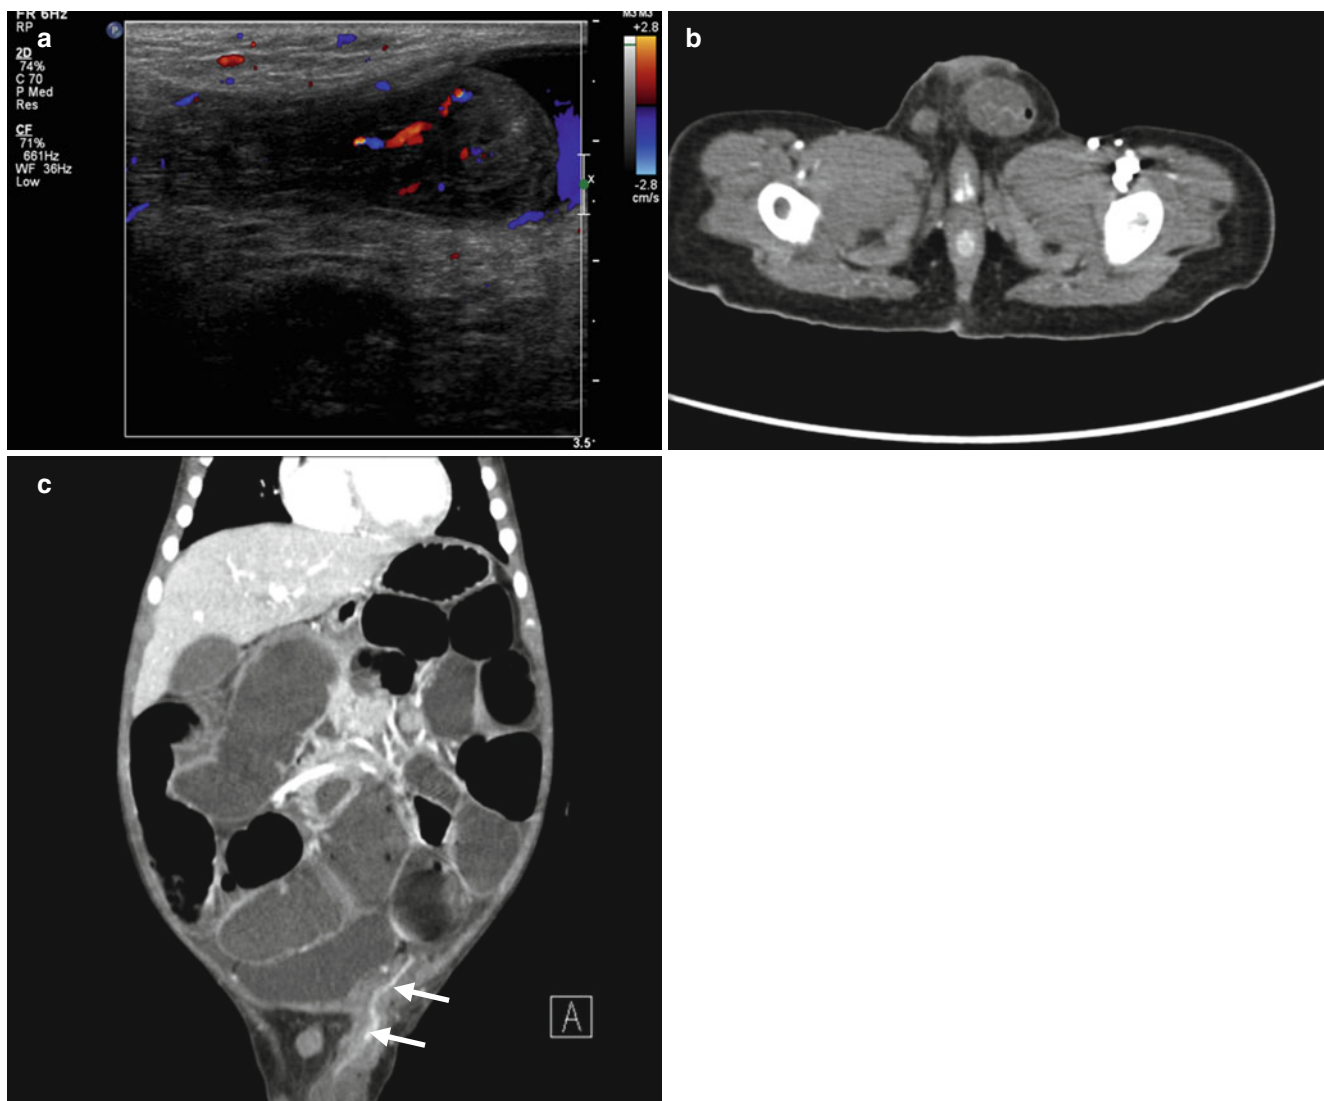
Left inguinoscrotal hernia in a 2-year-old boy with scrotal swelling. (a) Longitudinal color Doppler US scan shows a herniation of intestinal loop and echogenic omentum into scrotum, and blood flow
